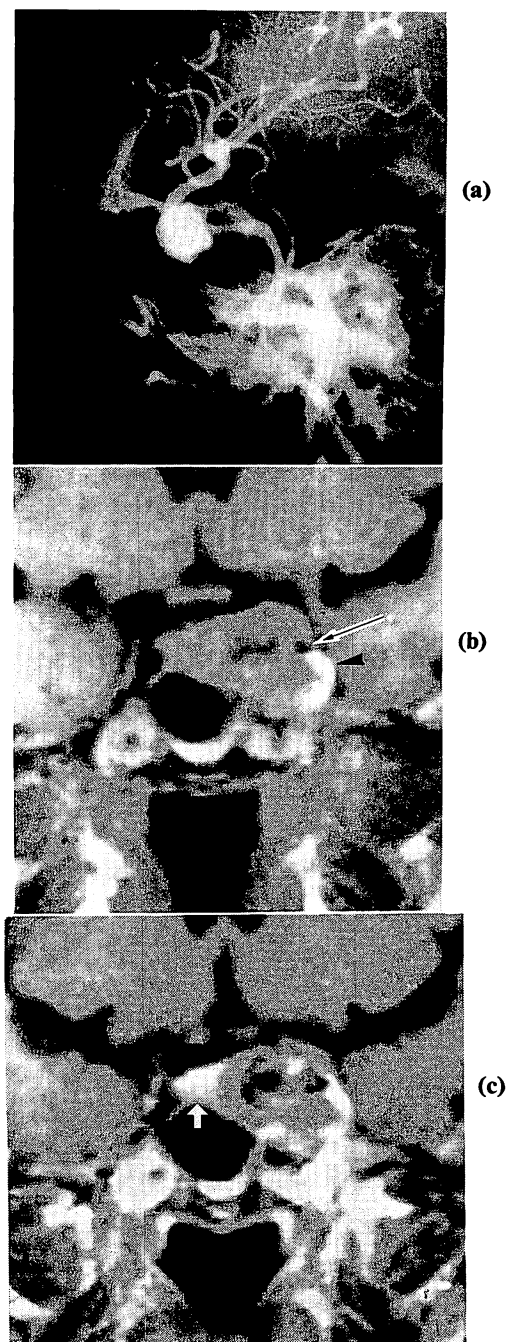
Partially thrombosed giant aneurysm. a: Common carotid injection shows an aneurysm at the cavernous sinus. It is not clear whether there is a thrombosis in the aneurysmal lumen. b: Plain MR image shows the small patent arterial flow as an area of signal void (*arrow*). The thrombosis exhibits heterogeneous signal intensity. The relationship between the thrombosis, the patent arterial flow, and the optic chiasm is clearly shown. The small high intensity area at the lateral wall of the aneurysm is probably caused by methemoglobin within the thrombosis (*arrowhead*). c: Image enhanced with Gd-DTPA shows the enhanced pituitary gland (*arrow*), while the patent carotid flow is an area of signal void. The aneurysmal lumen shows heterogeneous intensity.
